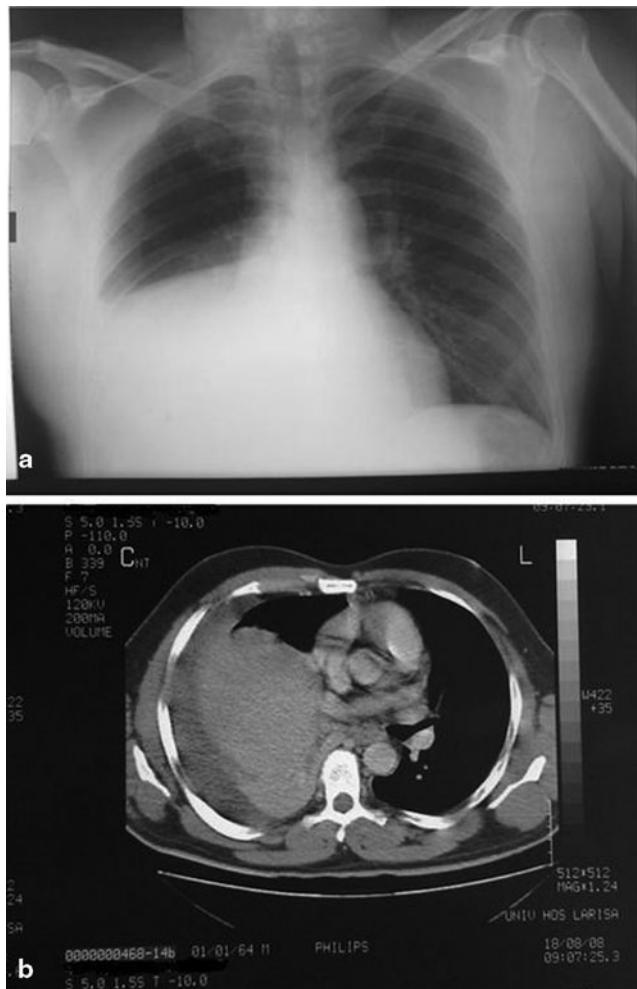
a Chest radiography shows elevation of the right hemidiaphragm, suggesting the presence of a pleural effusion. b Thoracoabdominal computed tomography shows the liver in a high position in relation to the right hilum. Pleural effusion is also identified. The loss of the peripheral air between the posterior ribs and the upper part of the liver indicates diaphragmatic rupture
